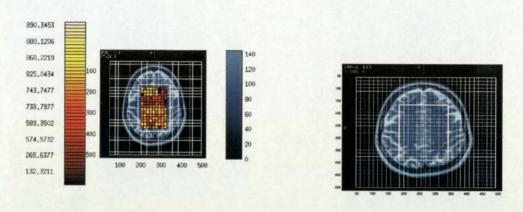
Gadolinium-enhanced MRI scan for a healthy volunteer with and without NeuroScale distances mapped on top (Euclidean distance).
